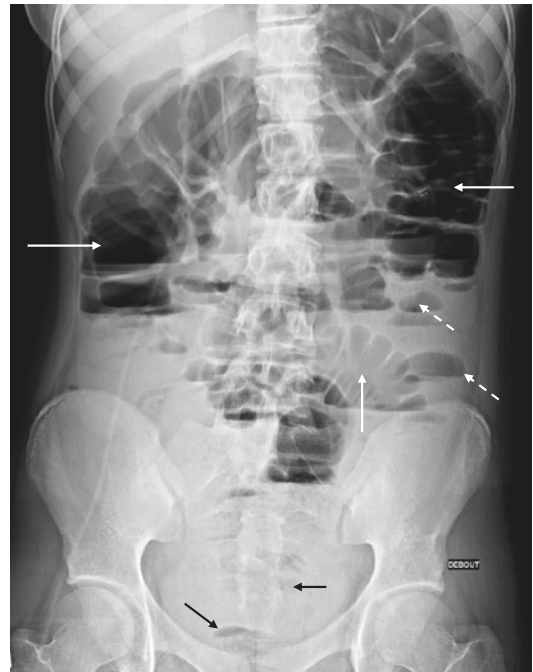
Functional intestinal obstruction in a 14-year-old girl with abdominal pain and distension after gastrostomy catheter insertion. Upright abdominal radiograph shows multiple air-fluid levels of various lengths in the large-bowel (arrows) and small-bowel (dotted arrows). Air is visible in projection of the rectum (black arrows)
